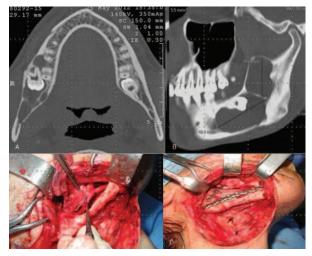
Computed tomography scan shows an extensive multiunilocular and hypodense image, axial (A) and sagittal (B) views. The lesion involves the body and the ramus of the right mandible with the presence of the unerupted wisdom tooth. Intraoperative view: the inferior alveolar nerve was identified, dissected, and preserved (C), the gap was reconstructed by iliac crest bone graft, fixed with titanium plates and screws (D).
